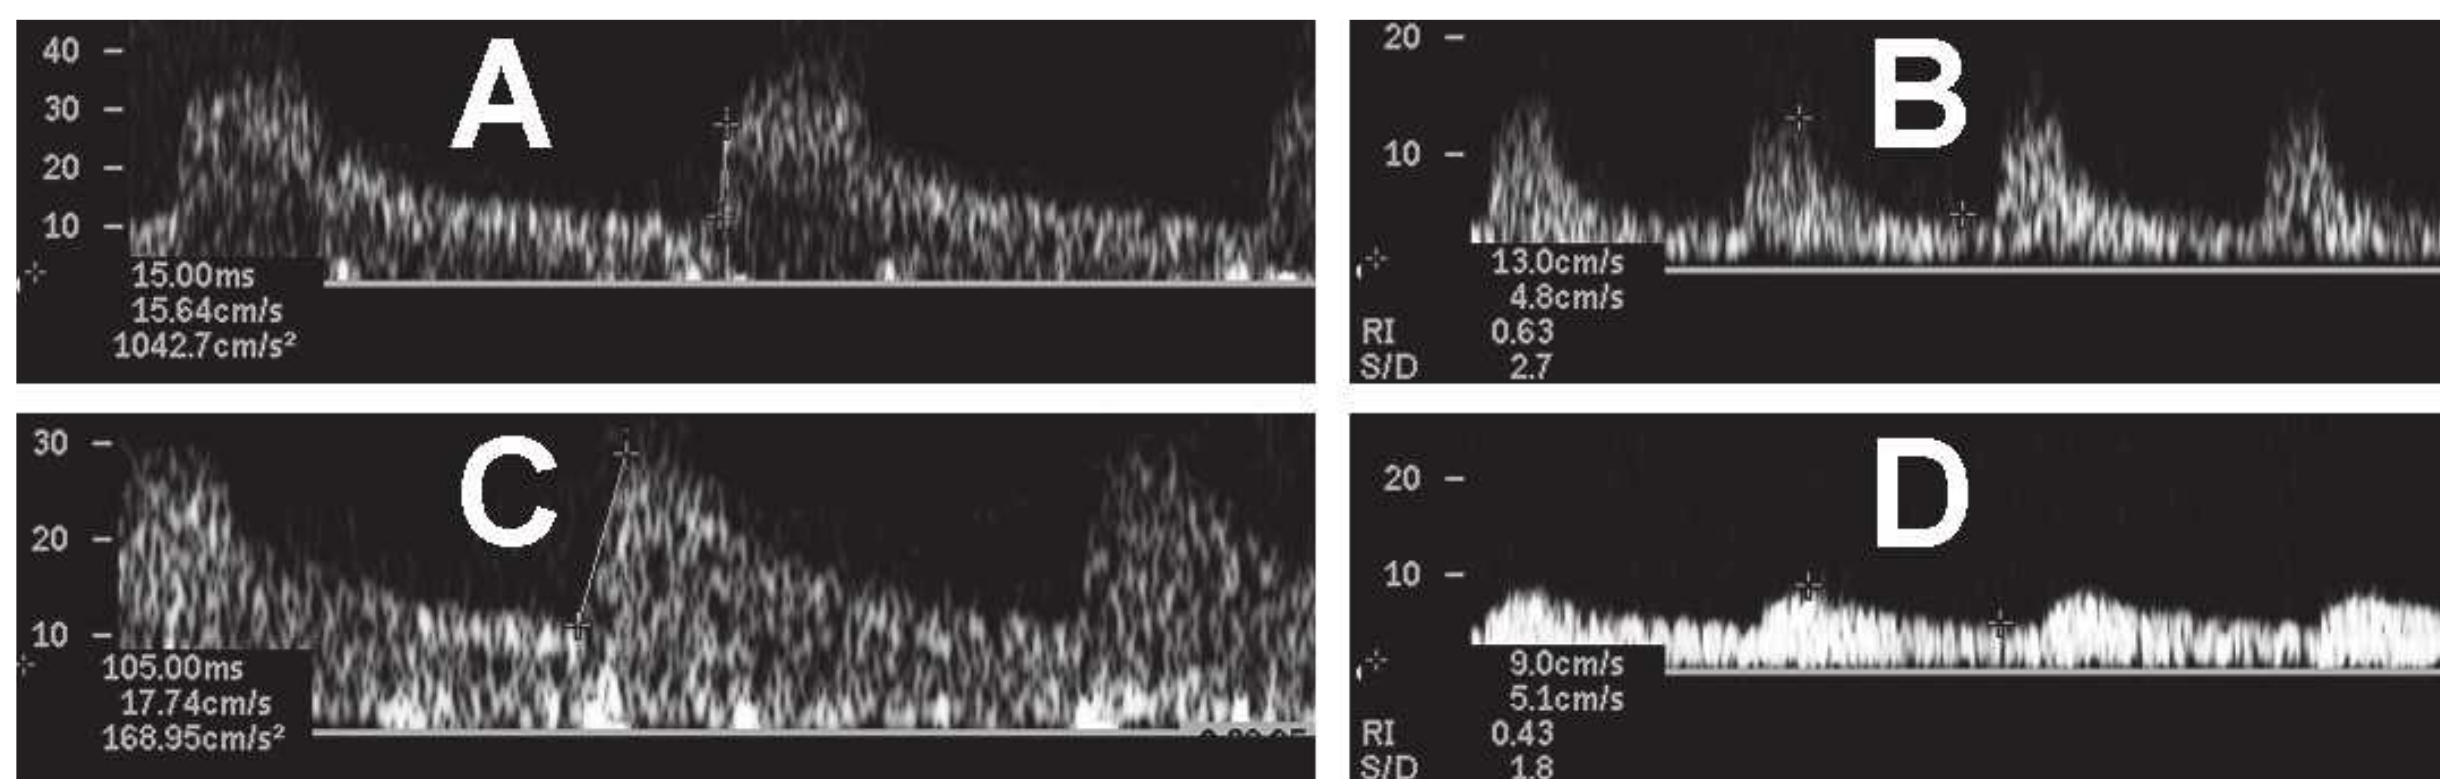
Intrarenal Doppler waveforms. A: Normal segmental artery with maximum systolic acceleration of approximately 1000 m per sec². B: Normal intraparenchymal artery. C: Segmental artery with maximum systolic acceleration less than 200 m per sec², indicative of renal artery stenosis. D: Intraparenchymal artery showing marked delay and blunting (tardus-parvus) of the systolic peak consistent with severe renal artery stenosis. (Images courtesy of Sue Zellman, RDMS, RVT.)
